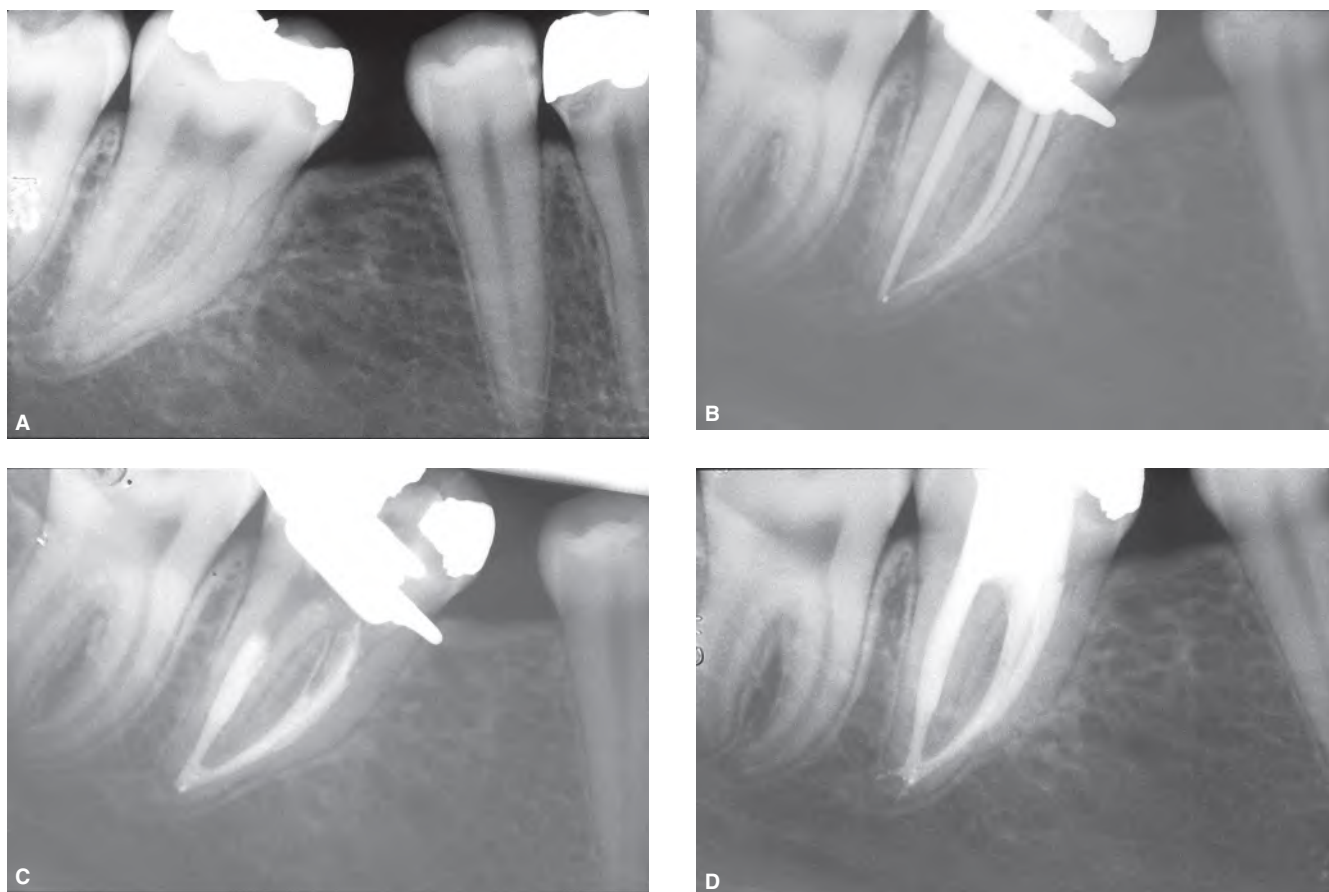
A.* Preoperative radiograph of a mandibular right second molar. *B.* Cone fit. *C.* Intraoperative radiograph of the apical compaction. The material appears to be homogeneous, but the obturation is slightly short. It is necessary to descend further apically (5 mm from the working length) with the heat-carrier and compact the gutta-percha better. *D.* Postoperative radiograph showing filling material also in the small apical bifurcation.
